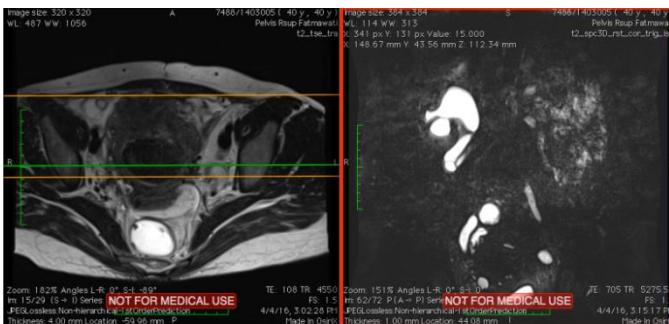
MRI findings suspected right ureter endometriosis
